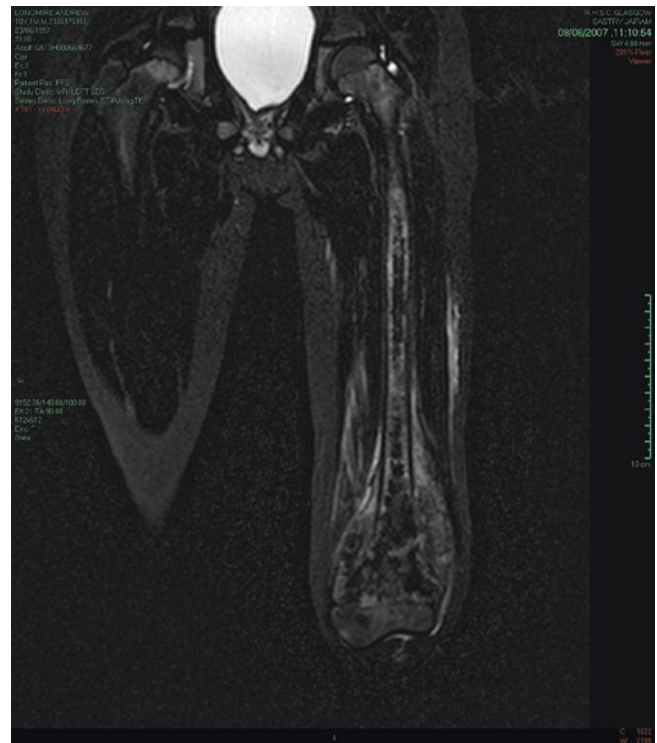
Aggressive features of osteosarcoma on coronal STIR MRI, including cortical destruction periosteal reaction, and oedema in the surrounding musculature
